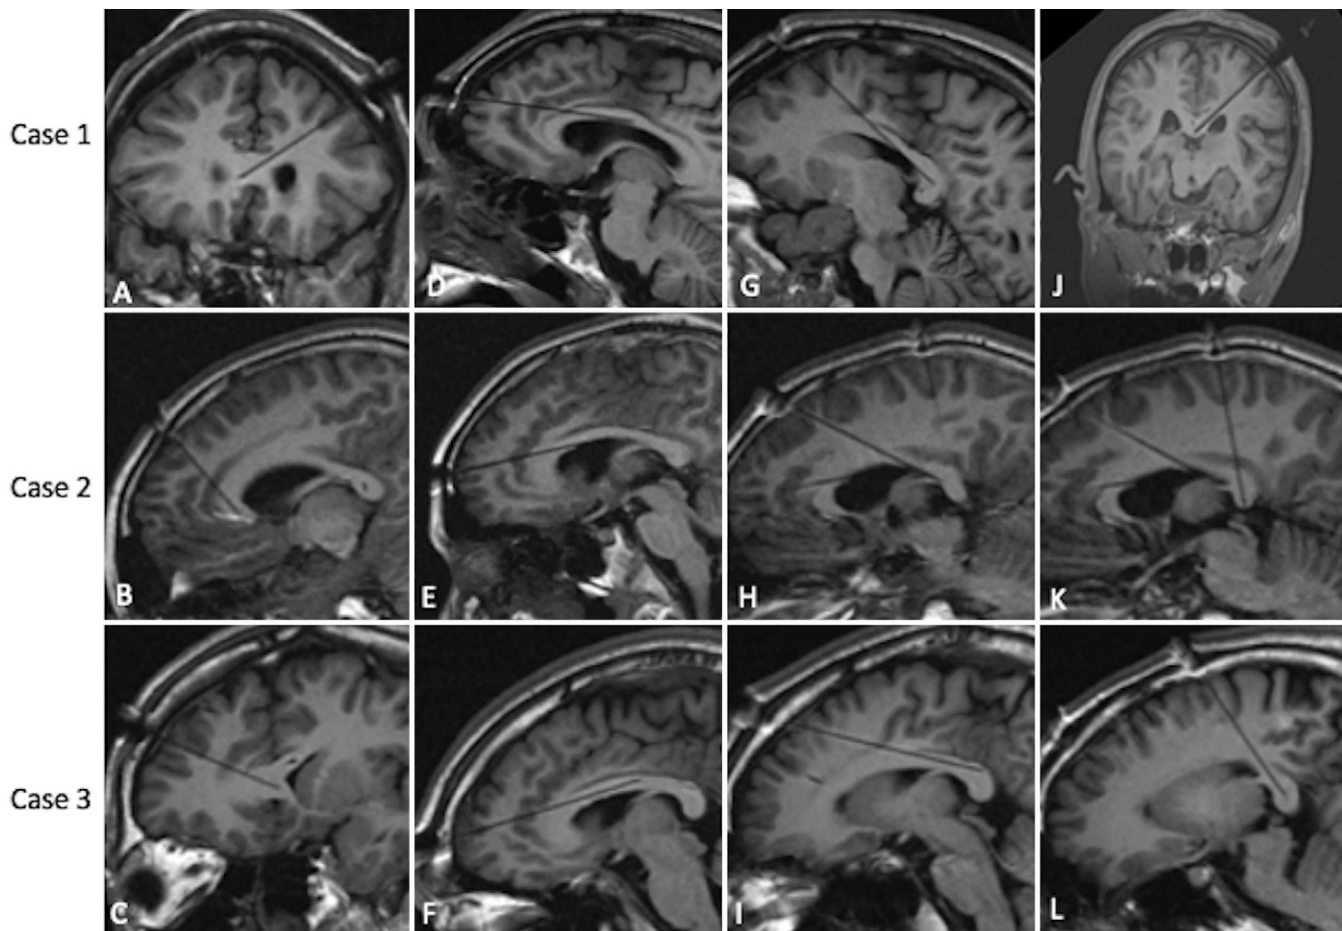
T1-weighted MRI sequences for all 3 cases obtained before ablation showing catheter trajectory with targets of the genu (A–C), anterior and middle body (D–F), posterior body and splenium (G–I), and splenium of the corpus callosum (J–L).
